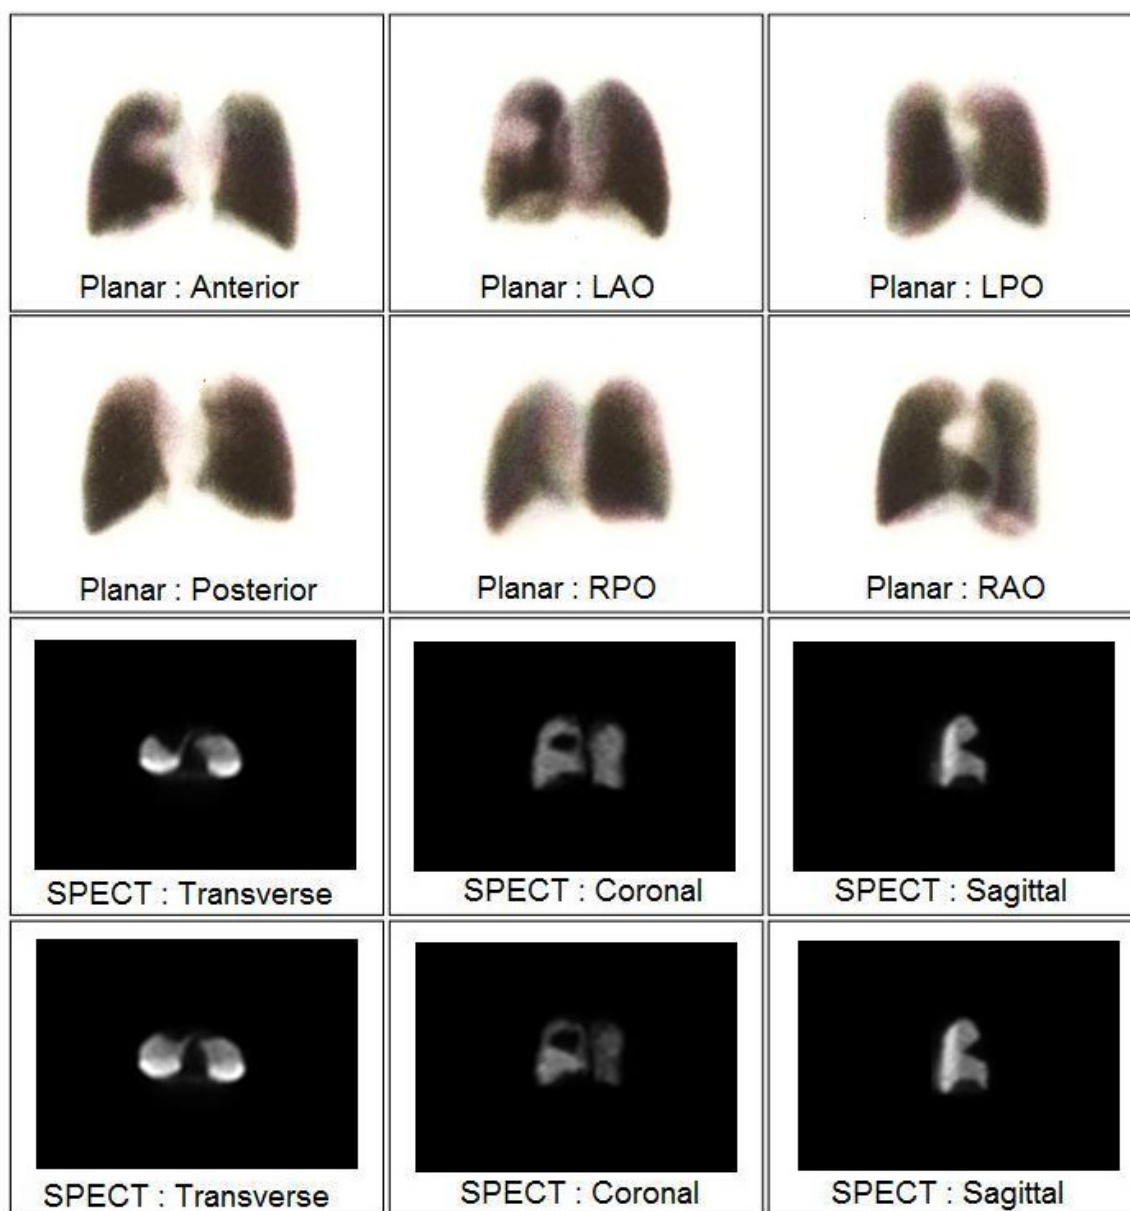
Planar and SPECT images of a perfusion defect within the anterior segment of the right upper lobe.
